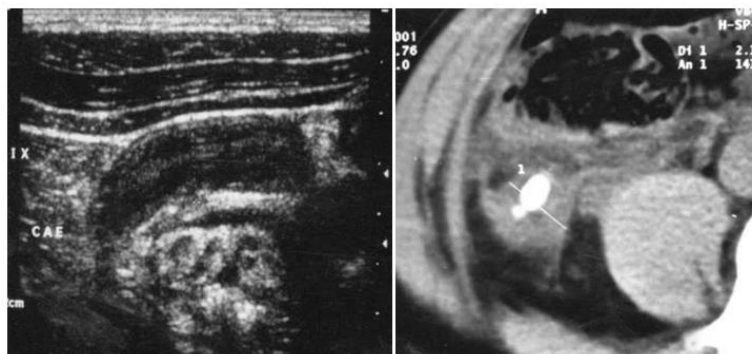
A and B: USG image showing inflamed dilated blind ending tubular Appendix. CT scan image depicting inflamed appendix (2.1cm) with surrounding fat stranding, right Psoas sign and Appendicolith
